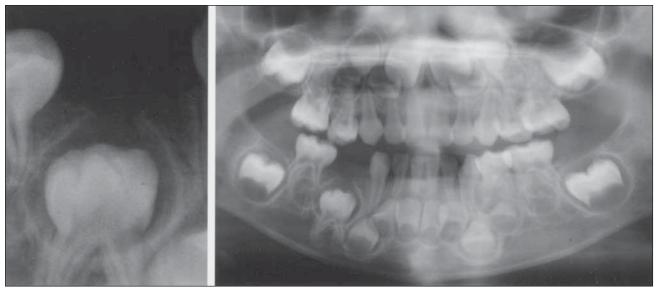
Radiographic appearance at 3 years, 7 months old.
